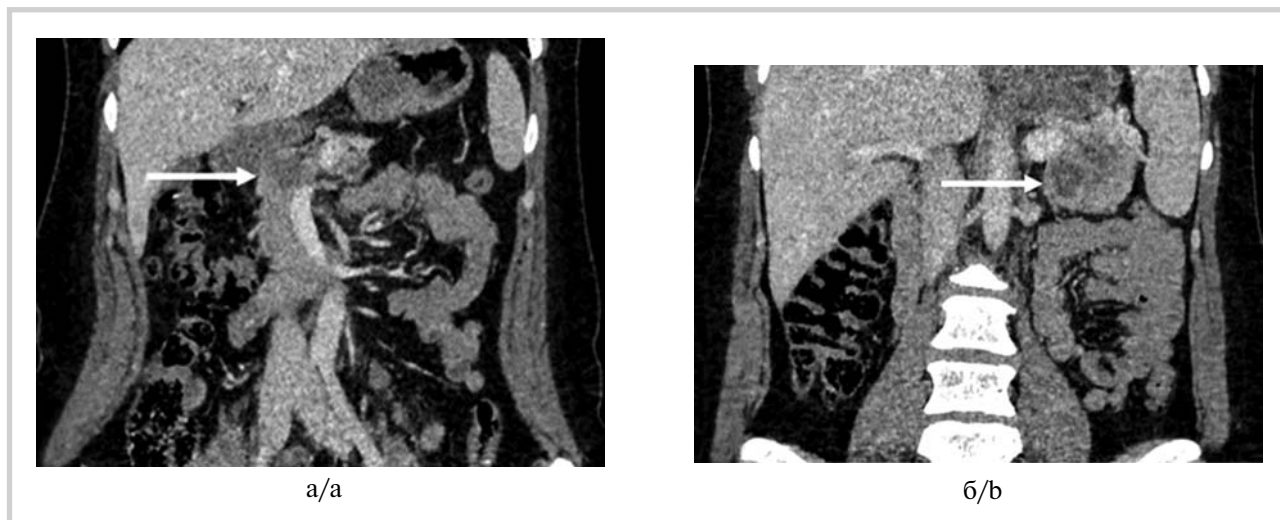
CT-scan, venous phase, frontal plane: A. IPMN of the pancreatic head associated with ductal adenocarcinoma. B. solid pseudo-papillary tumor of the pancreatic tail.
